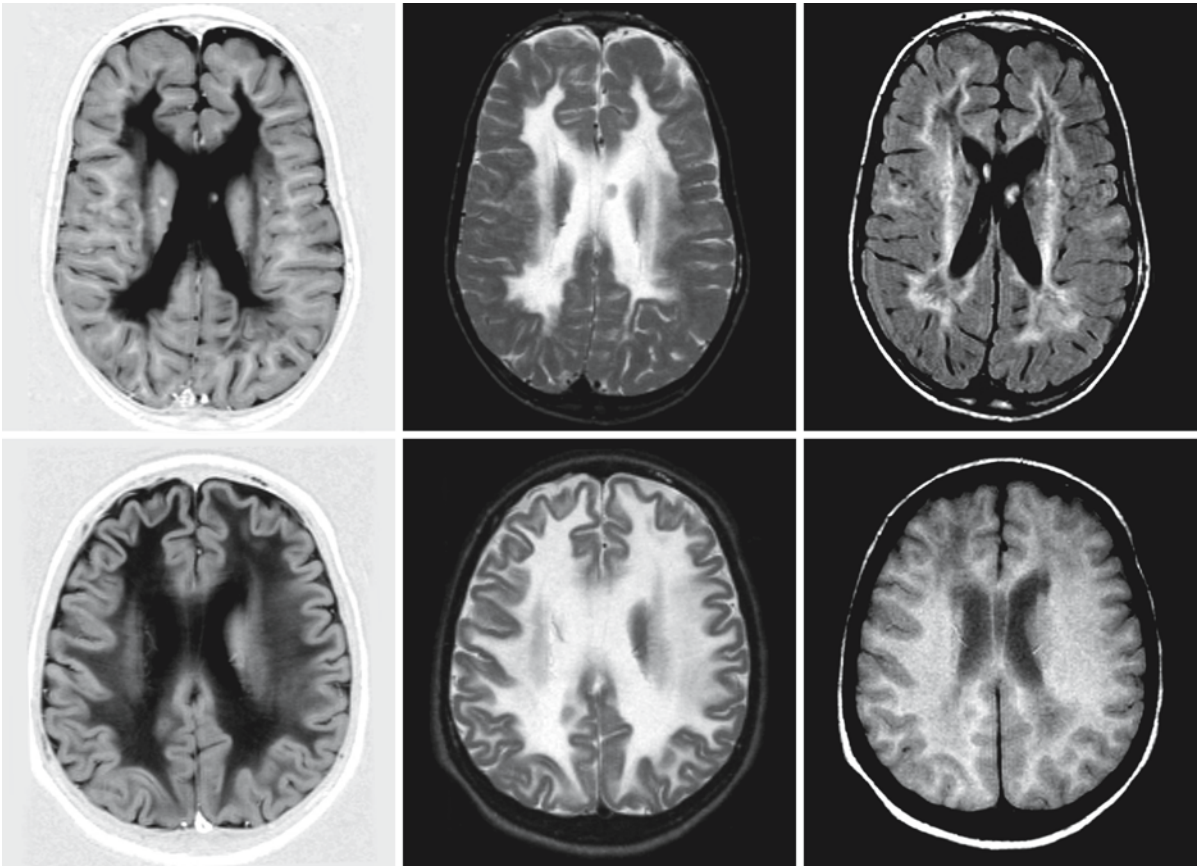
The *first* row of images originates from a 9-year-old girl with VWM, the *second* row from a 16-year-old girl with VWM. The T_2 -weighted (*middle*) and FLAIR or proton-density (*right*) images reveal the characteristic features of VWM. The IR image (*left*) shows that the U fibers are spared in the first patient, whereas they are affected in the second patient
